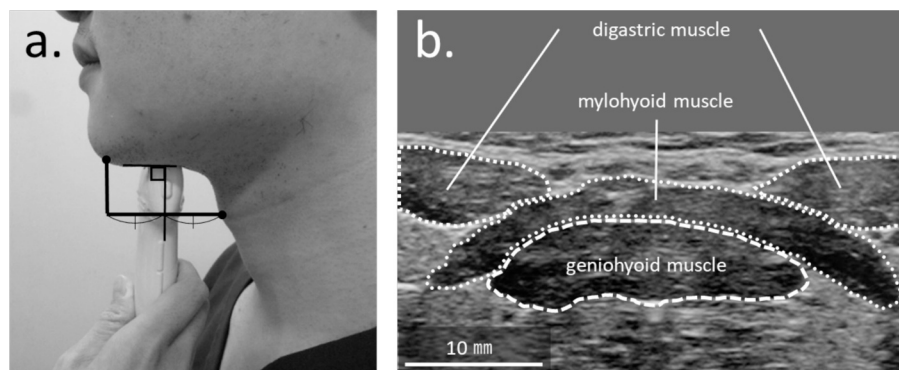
Measurement of the geniohyoid muscle cross-sectional area. The cross-sectional area of the geniohyoid muscles in participants with severe motor and intellectual disabilities was measured using an ultrasonic diagnostic device. (a) Measurement position: A 6.0-MHz linear transducer was placed perpendicular to the submandibular skin at the midpoint between the participant's mandibular chin and maximum thyroid cartilage prominence. (b) Measurement of the cross-sectional area: The cross-sectional area of the geniohyoid muscle drawn in the deep layer of the coronal section was measured.
